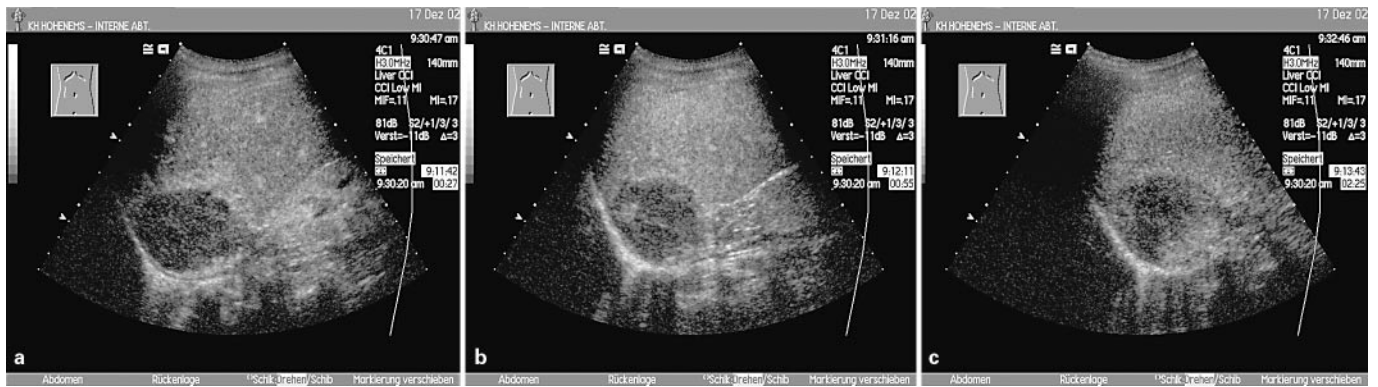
Signal-enhanced ultrasound of a haemangioma. 27 s after injection a rim-like enhancement is visible (a). 55 s after injection it shows a globular enhancement (b) with progressive centripetal fill-in, which is not complete in this case (c).
